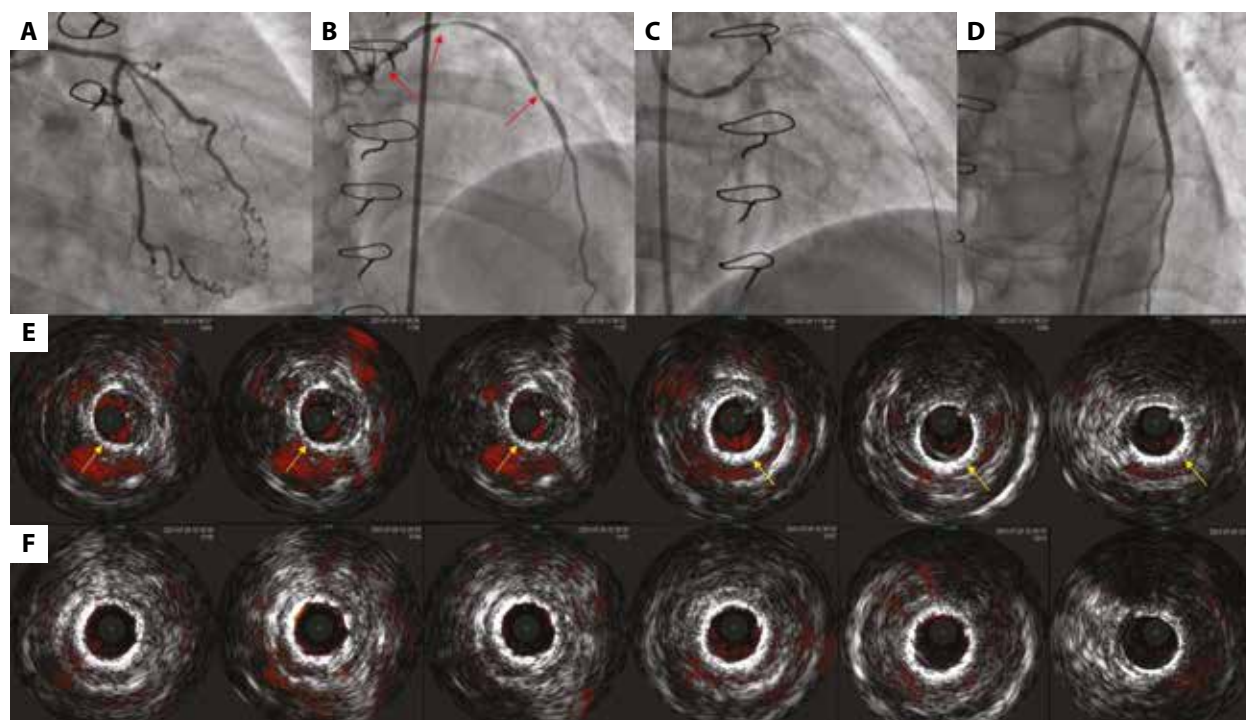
A. An anteriorposterior caudal angiographic view of the left coronary artery: significant stenosis of the left main and left circumflex artery (LCx). B. Saphenous vein graft (SVG) to the left anterior descending artery: significant stenosis of proximal, medial, and distal segments (red arrow). C. Non-compliant balloon underexpansion in the proximal segment of SVG. D. Intravascular ultrasound (IVUS) cross-sections of the proximal SVG after SIVL and stent implantation. E. Intravascular ultrasound (IVUS) cross-sections of the proximal SVG before shockwave intravascular lithotripsy (SIVL), calcium rings are marked with the yellow arrow. F. Final angiographic view of SVG
